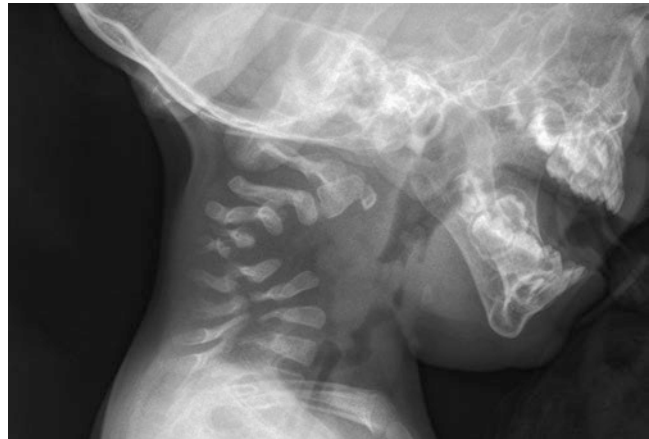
Resolution of kyphosis with age in a patient with diastrophic dysplasia. The radiograph on the left shows characteristic C5 kyphotic apex at 3 months of age.
